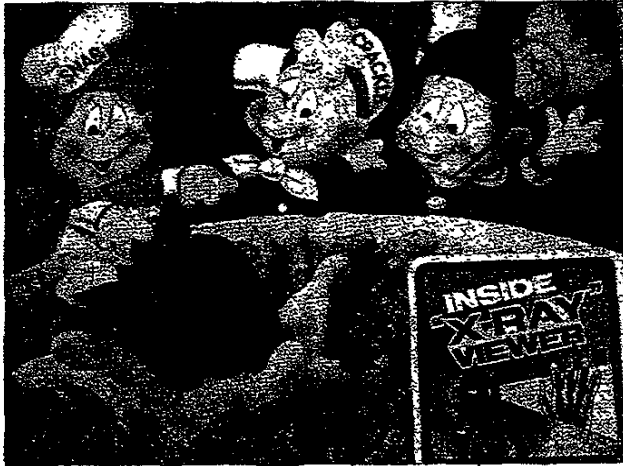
As this photograph of a 1990 cereal box attests, radiation remains fully assimilated into current culture. A careful look at the hands of this famous threesome, however, reminds us of the hazards of "x-ray" viewer overuse. (Courtesy of Kellogg Corporation.)
